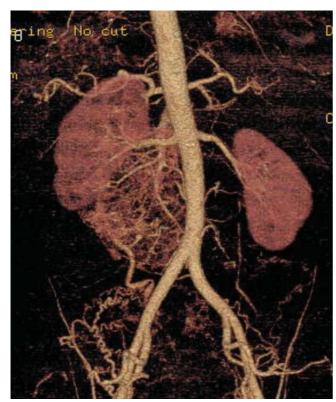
3D reconstruction of CT angiogram.
